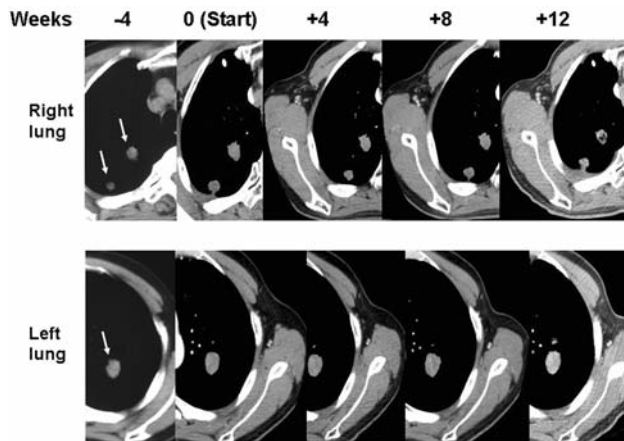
Representative data of computed tomographic examination. Arrows indicate tumors in the chest. The growth of tumors was suppressed by WT1 vaccination.
